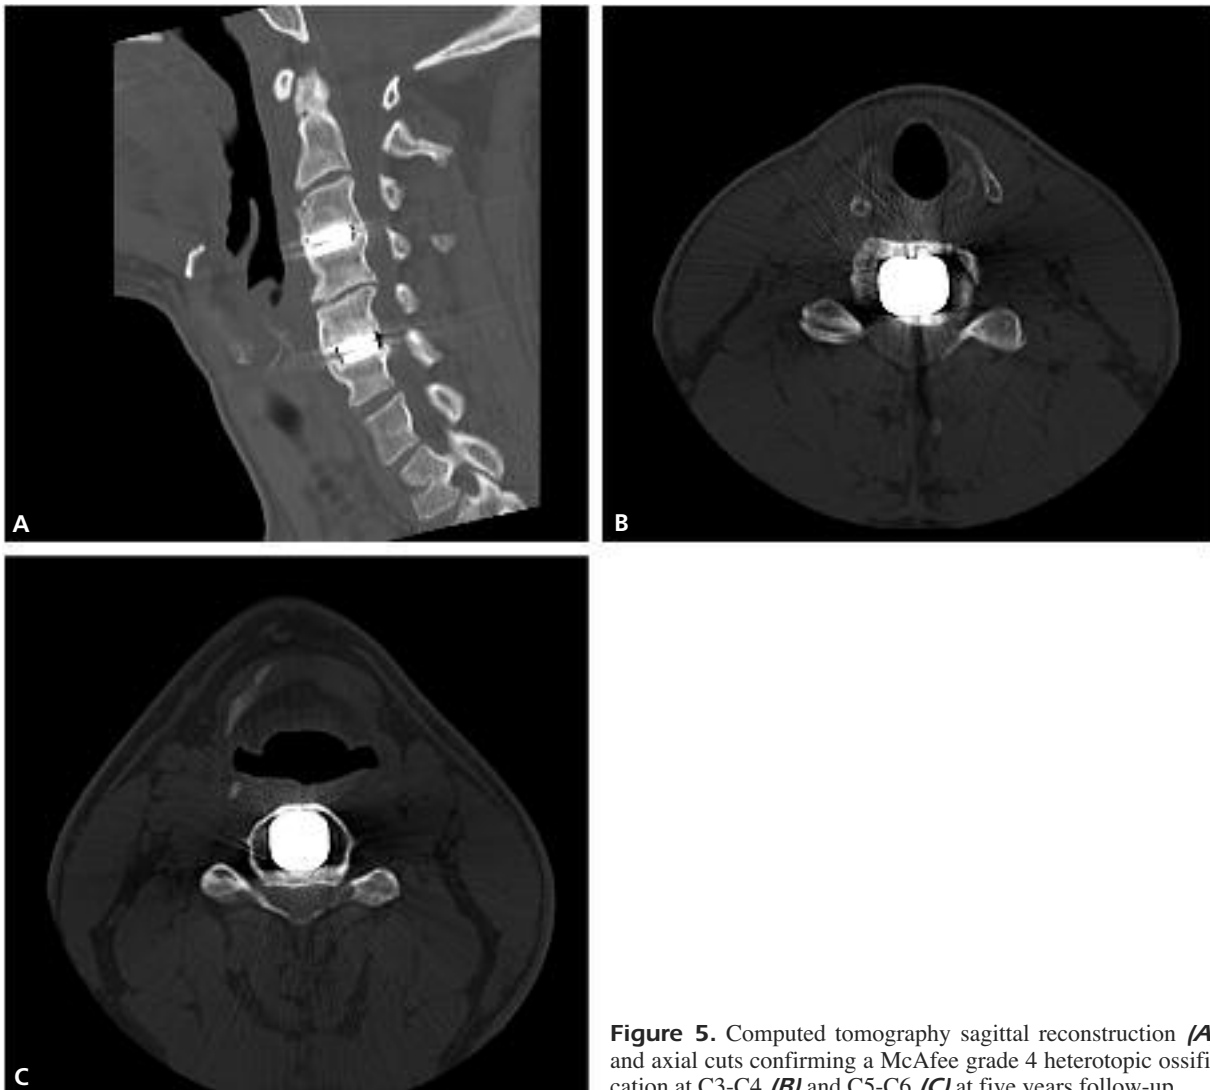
Computed tomography sagittal reconstruction (A) and axial cuts confirming a McAfee grade 4 heterotopic ossification at C3-C4 (B) and C5-C6 (C) at five years follow-up.
